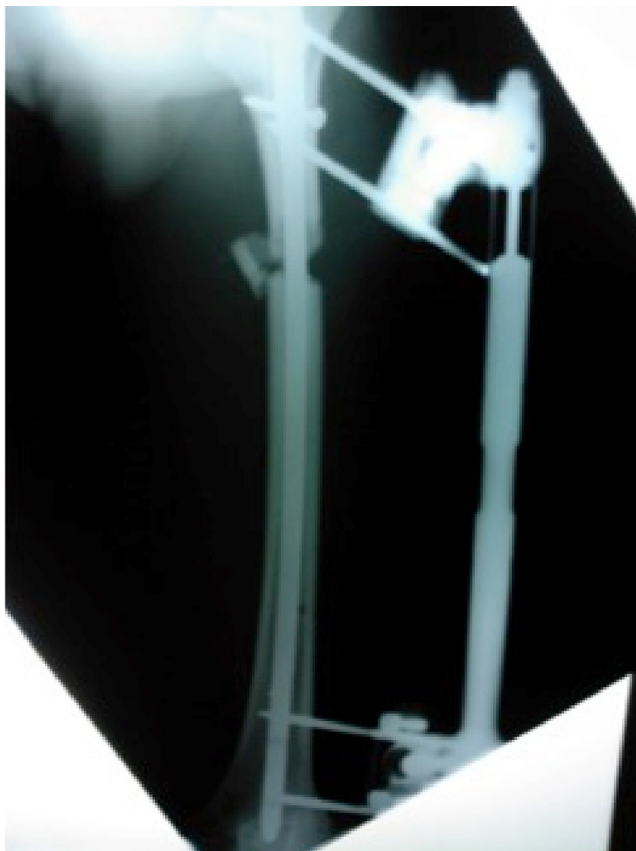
Radiographic image of a femur in the lengthening phase after osteotomy, undergoing lengthening.
